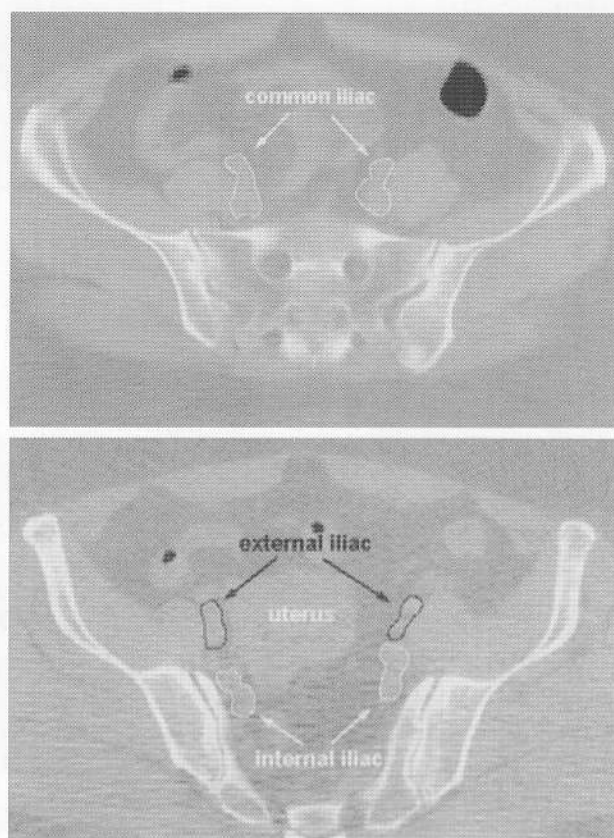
CT images of iliac vessels. Top: common iliac vessels. Bottom: the external and internal iliac vessels.
